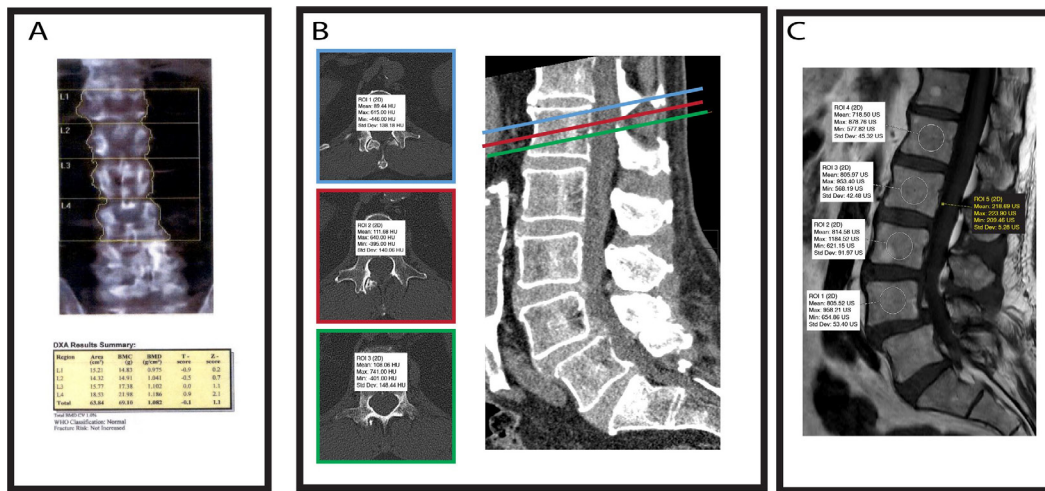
An 80-year-old man undergoing preoperative spinal imaging. (A) Lumbar dual-energy x-ray absorptiometry scan. (B) Hounsfield unit (HU) bone mineral density at a given level is calculated as the average HU of the superior endplate, middle of the vertebral body, and the inferior endplate. (C) Vertebral bone quality is calculated by dividing the median signal intensity of the medullary portions of L1–L4 vertebral bodies by the average signal intensity of the cerebrospinal fluid at L3.
